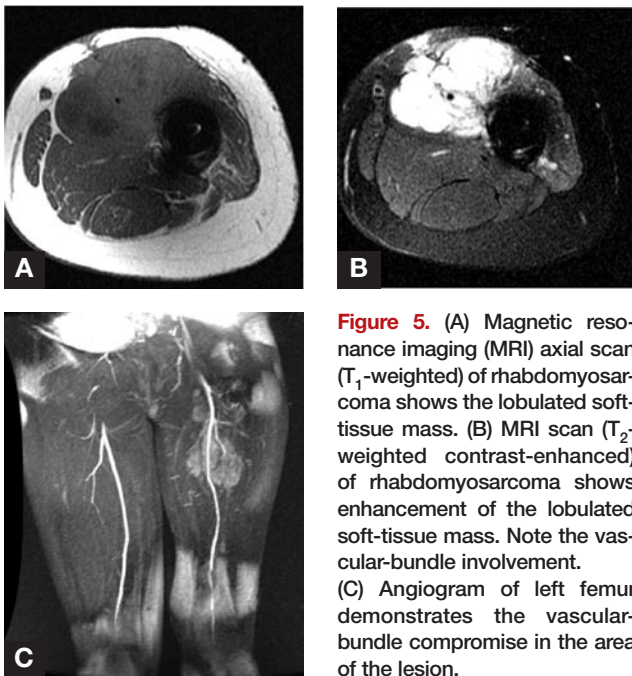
(A) Magnetic resonance imaging (MRI) axial scan (T_1 -weighted) of rhabdomyosarcoma shows the lobulated soft-tissue mass. (B) MRI scan (T_2 -weighted contrast-enhanced) of rhabdomyosarcoma shows enhancement of the lobulated soft-tissue mass. Note the vascular-bundle involvement. (C) Angiogram of left femur demonstrates the vascular-bundle compromise in the area of the lesion.
